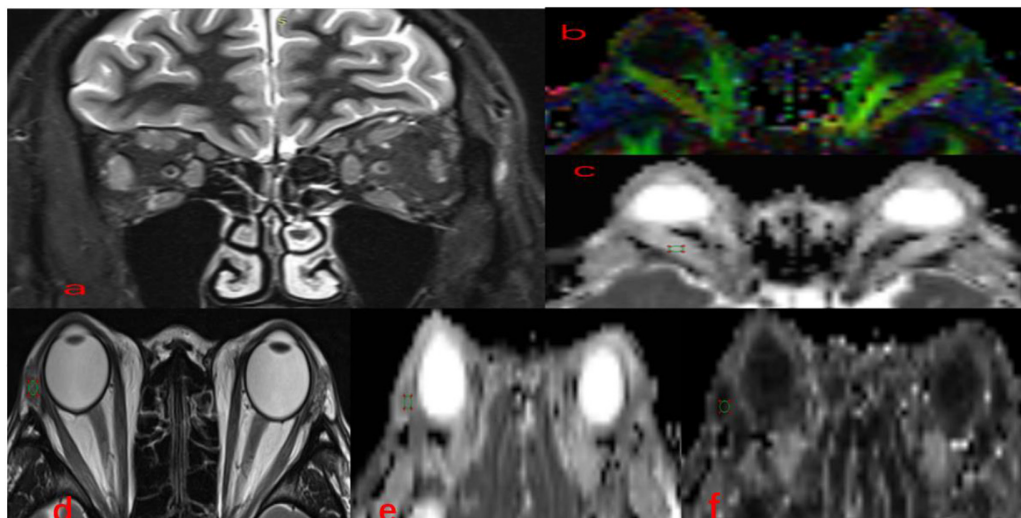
Methods for DTI parameters measurements in EOMs and LG. Coronal (a) fat-suppressed T2-weighted images and color-coded FA (b), MD (c), in a 36-year-old man with TAO. A circular region of interest was manually set on each EOM locating the clearest cross-section. Axial (d) T2-weighted images, FA (e), MD (f) maps of the same patient. A circular region of interest was manually set on each LG indicating the clearest cross-section. TAO, thyroid-associated ophthalmopathy; EOMs, extraocular muscle; DTI, diffusion tensor imaging; LG, lacrimal gland; FA, fractional anisotropy; MD, mean diffusivity.
